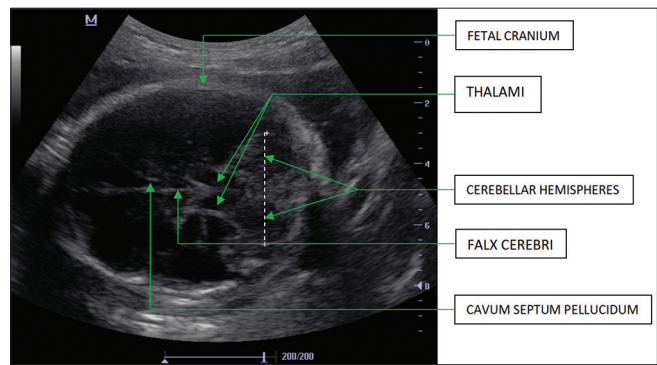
B-Mode transaxial sonographic appearance of Grade IIb cerebellum at 30 weeks GA showing an echogenic vermis connecting oval-shaped cerebellar hemispheres giving the “dumbbell” appearance. GA: Gestational age
